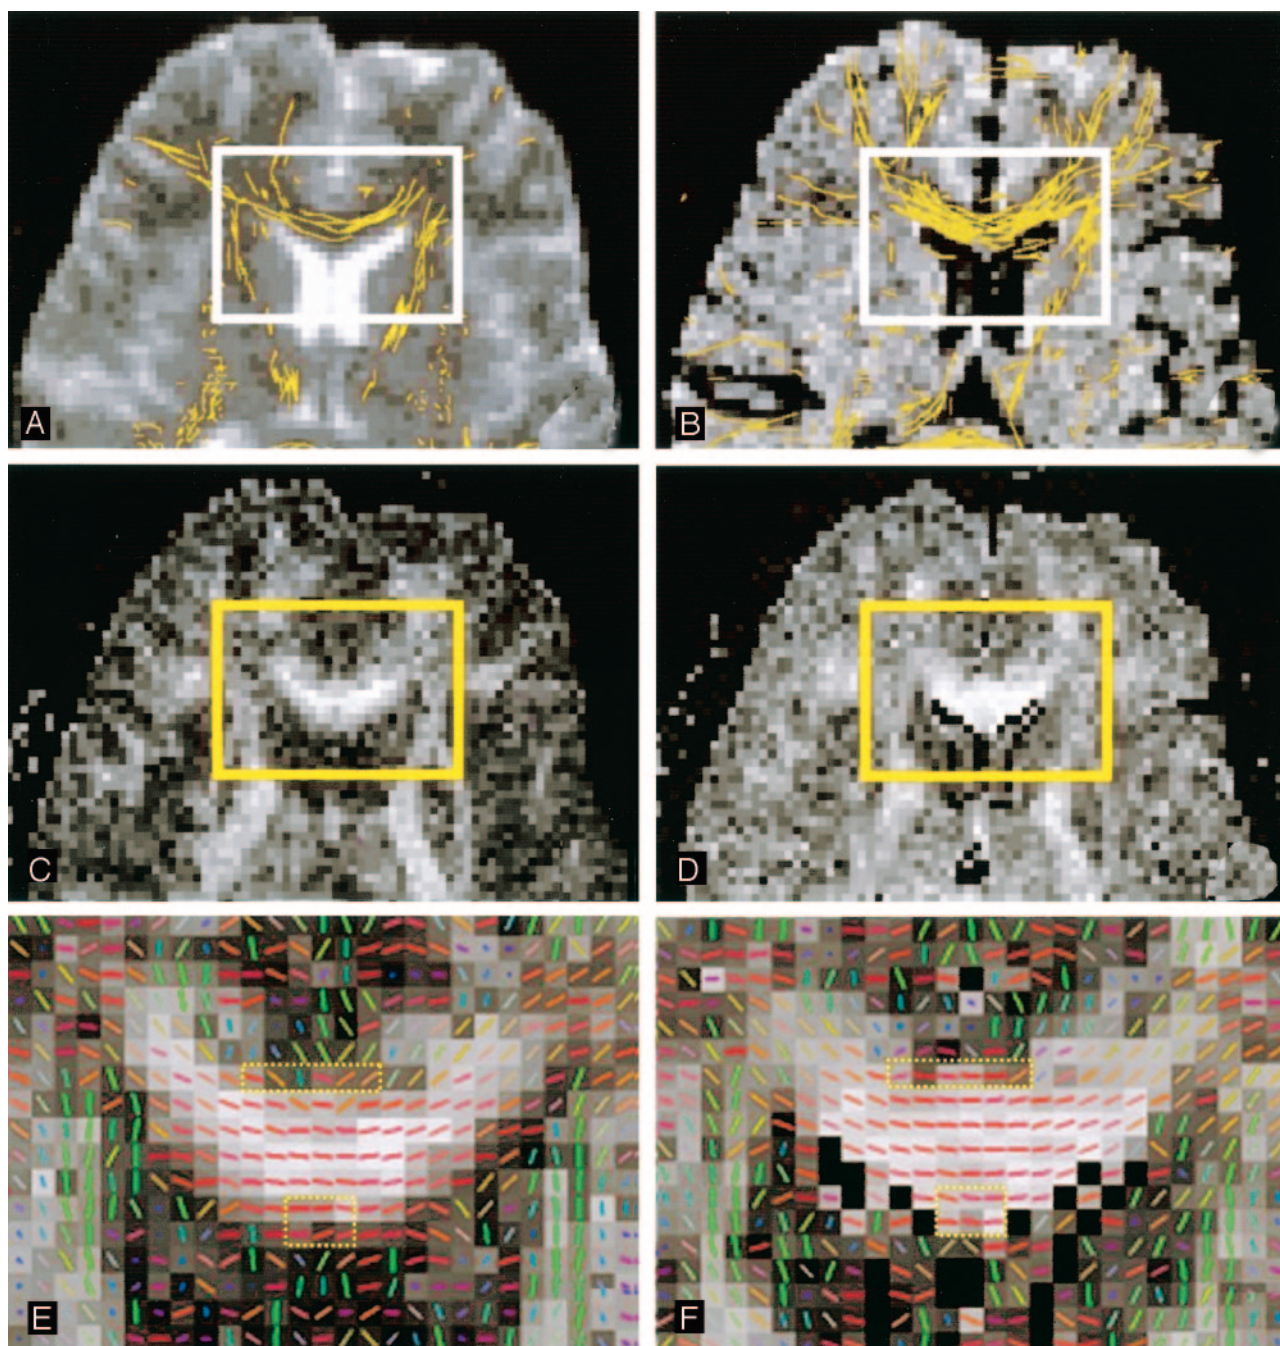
Anterior aspects of an image section obtained in a 23-year-old man show white matter tracts superimposed on images A–F magnified from the rectangular region-of-interest (solid rectangles). Partial volume effects near adjacent CSF lead to underestimation of FA in the genu of the corpus callosum on conventional DTI (left column and dashed rectangles in E.) Note the less consistent fiber directions and the darker gray level, which indicates lower FA values. These effects account for the smaller amount of fibers found with the tracking algorithm on conventional DTI than on FLAIR DTI (right column, dashed rectangles in F). Note the more consistent fiber directions and the brighter gray level, which indicates higher FA values.
